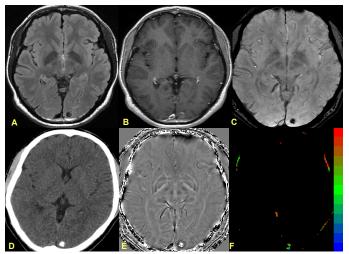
Showing A-F, T2 FLAIR, POST CONTRAST T1, SWAN, CT, Phase and RGB- K_{ep} map of a 29-yrs-old male, presented with seizures
